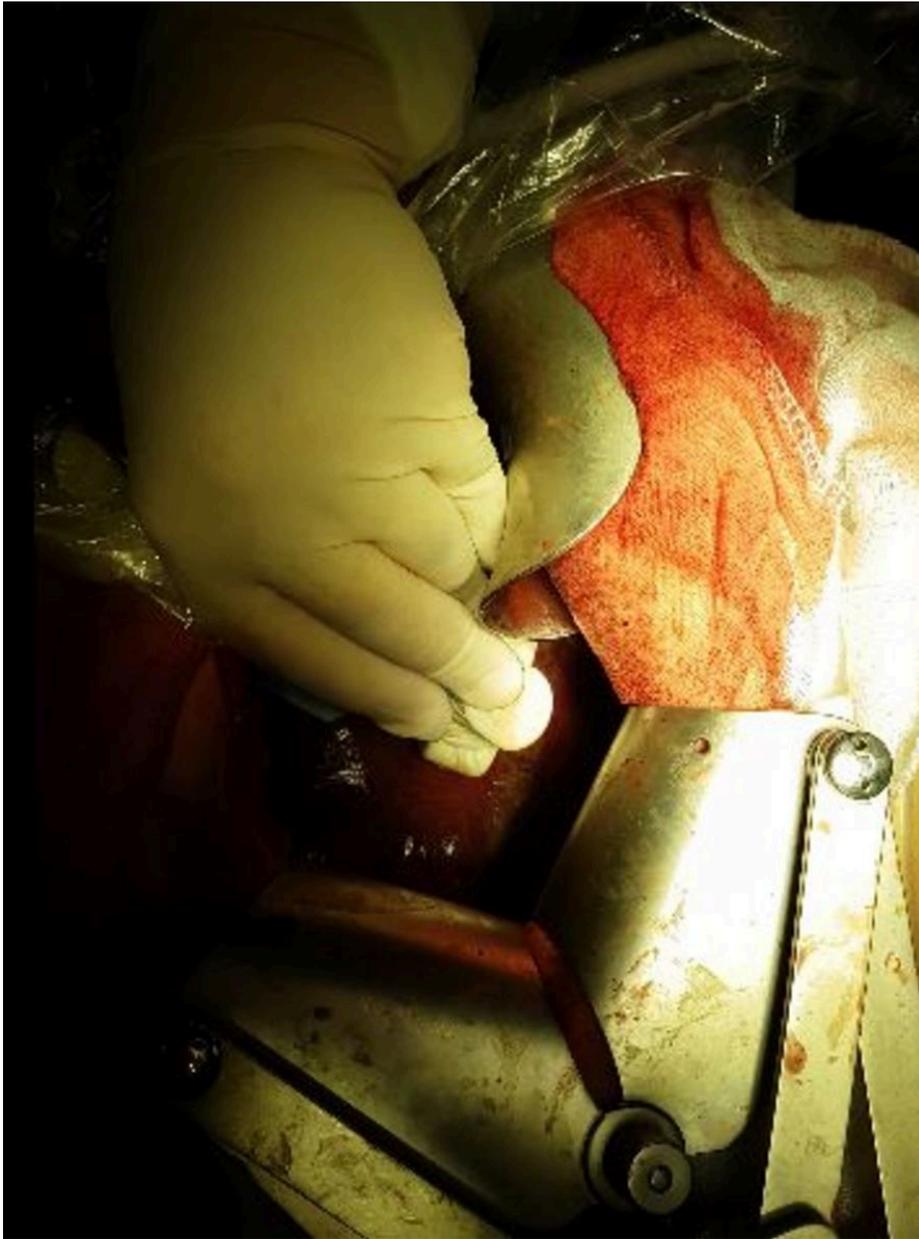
Intraoperative ultrasound of the liver using a T-shaped transducer.
